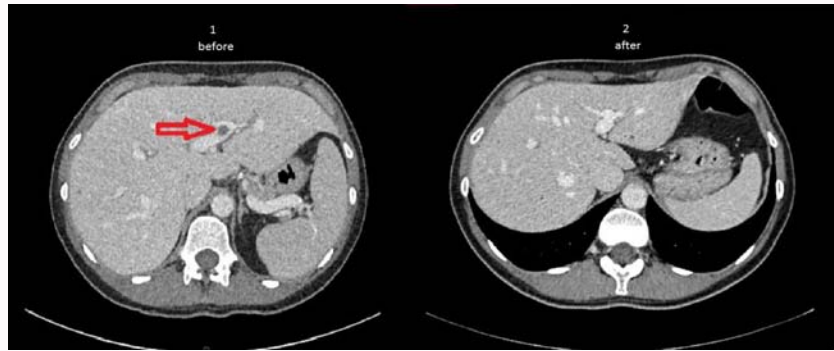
(1) Shows portal vein thrombosis on a CT scan of the liver (performed with infusion of contrast agent). (2) Shows the resolution of the portal vein thromboembolism six months later after anticoagulation with acoumarenol.
